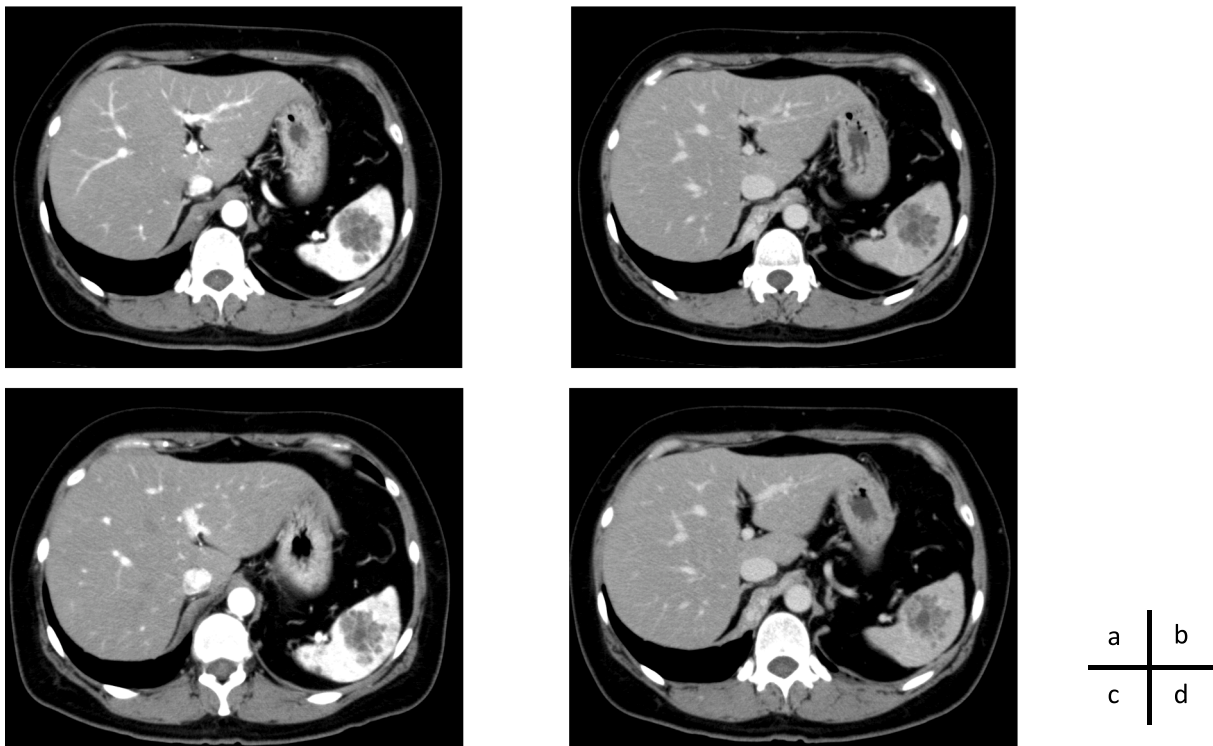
Contrast-enhanced computed tomography (CT) scans obtained in case 2
